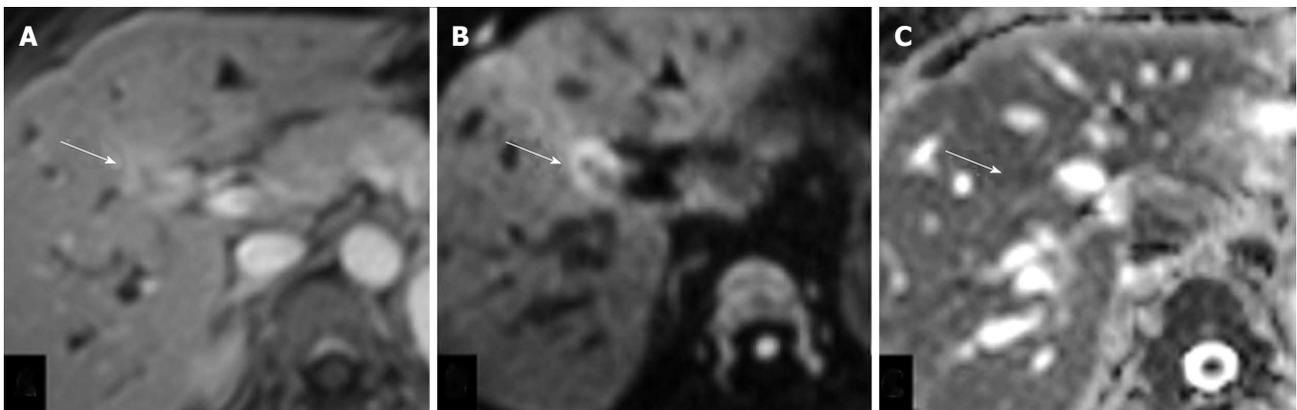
A case of periductal type of hilar cholangiocarcinoma. A: Axial T1-weighted contrast enhanced magnetic resonance (MR) image in delayed phase showing enhancing periductal lesion (arrow); B and C: Axial diffusion weighted b-800 MR images (B) and ADC map (C) showing diffusion restriction of the lesion.
